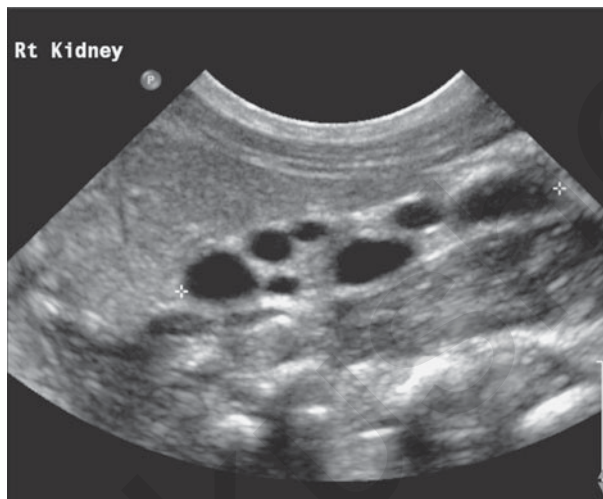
Right-sided multicystic dysplastic kidneys on ultrasound in a newborn patient. The cysts may vary in size, but are usually seen throughout the kidney(s) and the intervening parenchyma is echo bright. A true multicystic dysplastic kidney has no function on DMSA.
